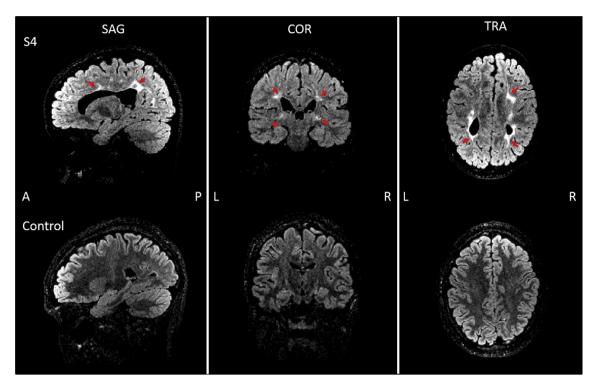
MRI FLAIR images from S4 (top row) and a healthy control subject (bottom row). In S4 areas of hyperintensity highlighted by red arrows identify PVL lesions. A: anterior; P: posterior; L: left; R: right; SAG: sagittal; COR; coronal; TRA: transversal view.
